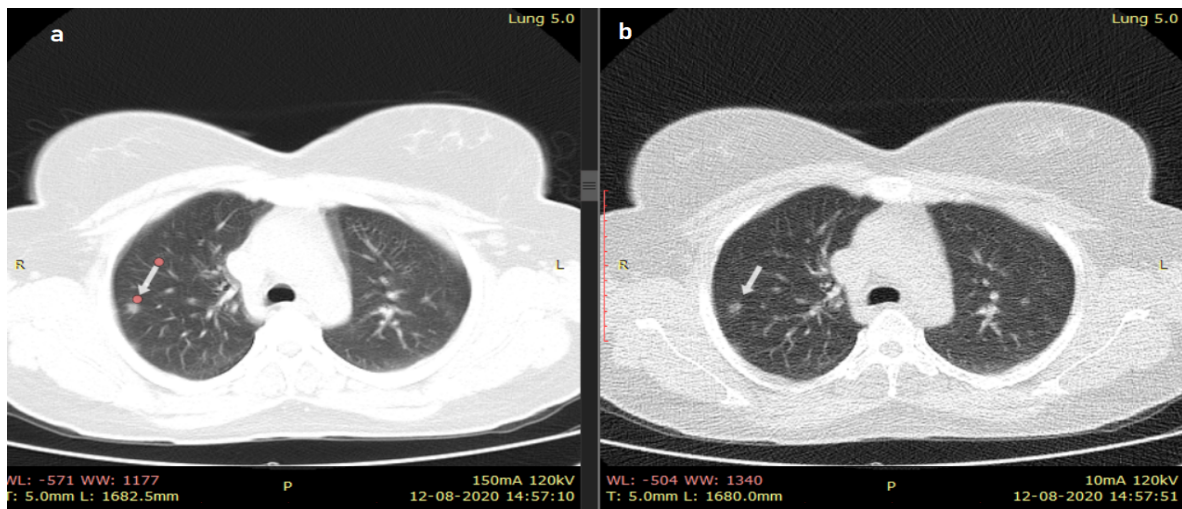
Chest CT Visualization of Small Ground Glass Nodule in COVID-19 Pneumonia Patient
